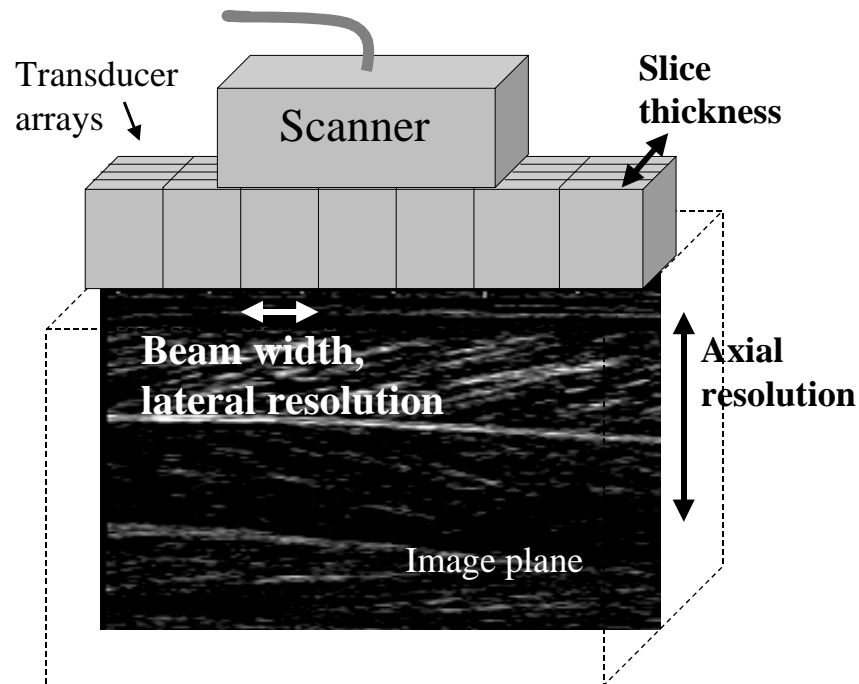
Ultrasound scanner with description of the different resolution directions.*
